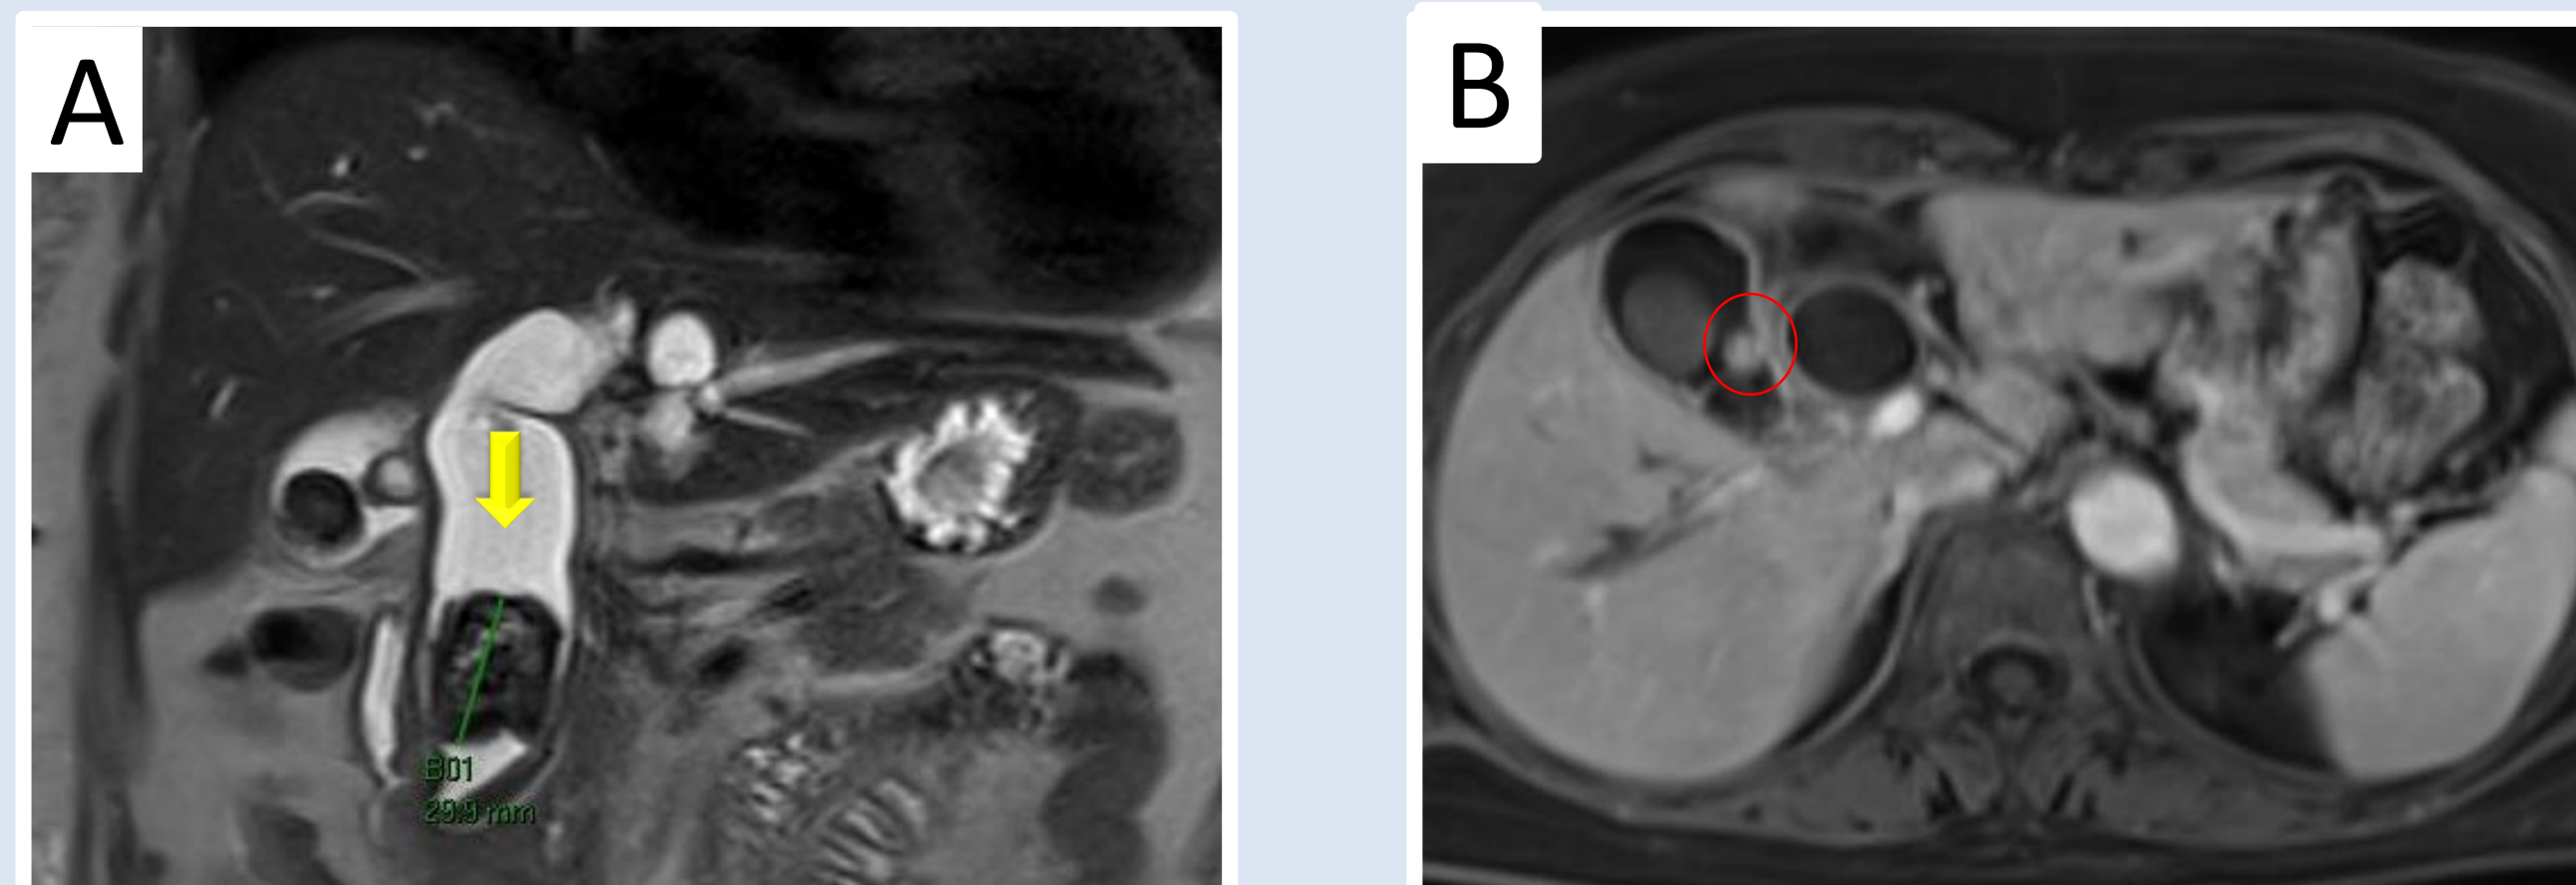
MRI Pancreas findings: (A) A 3cm common bile duct stone (yellow arrow)
